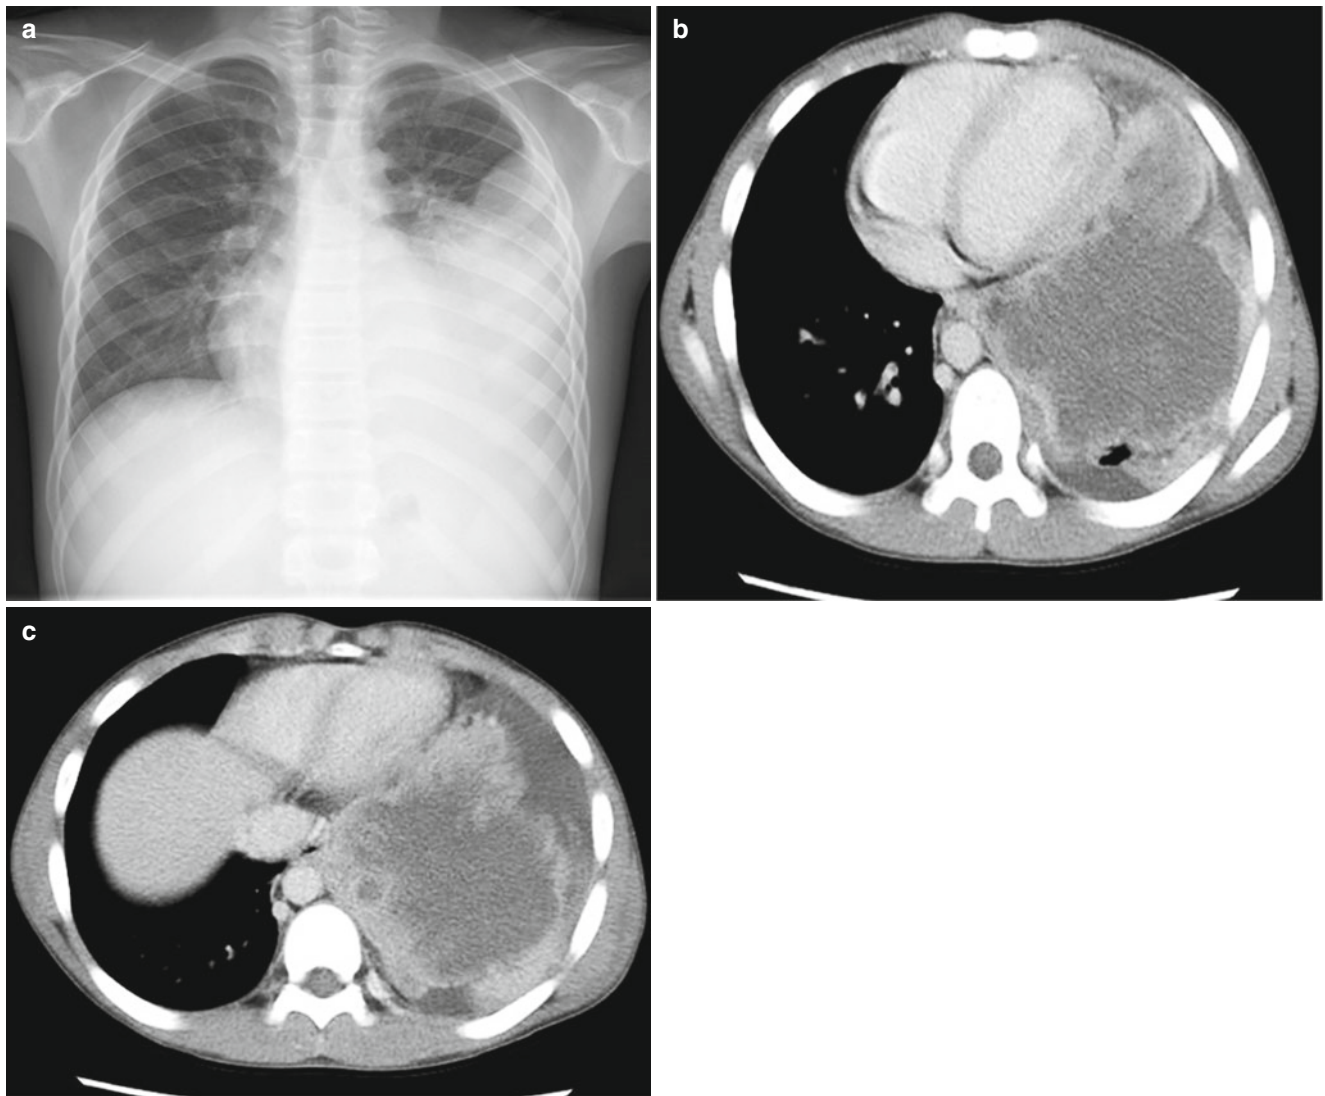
Pleuropulmonary blastoma in a 14-year-old boy. (a) Plain radiograph shows a large opacity in the left hemithorax. (b, c) Contrast-enhanced CT shows mixed cystic and solid masses in the lung
